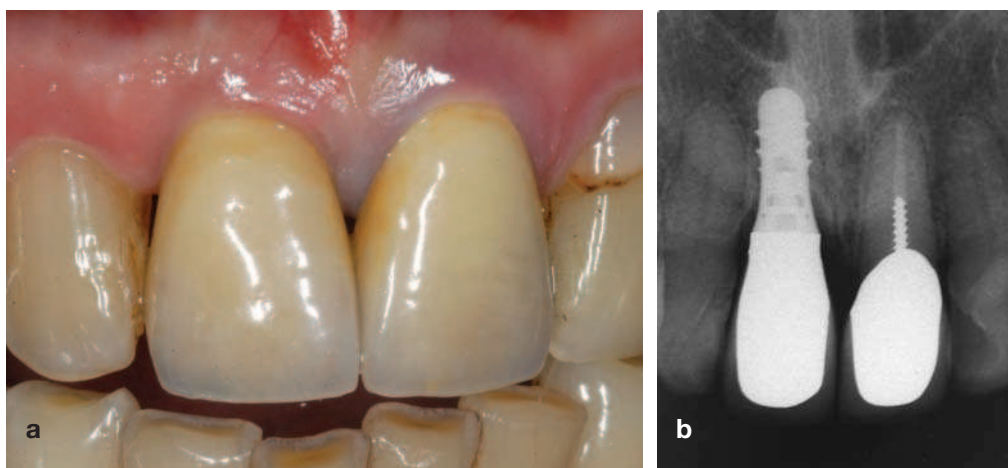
(a) Labial view of implant crown replacing the 11, adjacent to a natural tooth 21 that was restored with a crown. Note the intact interdental papilla present between the 11 and 21. (b) Radiograph of the clinical situation seen in Fig 5(a). Although the endodontic and restorative status of the 21 was less than ideal, retention of tooth 21 allowed maintenance of the interdental papilla between the 21 and the 11 implant.
